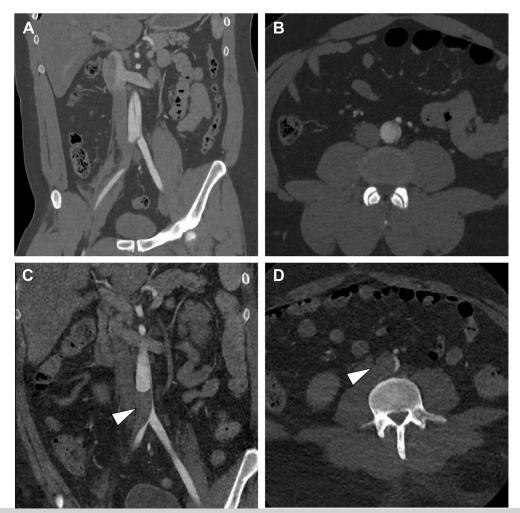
Computed tomography (CT) of abdomen and pelvis of patient 1 in coronal (A) and axial (B) planes at presentation. Similar locations on the repeat CT scan at the time of open aortic septectomy are shown in the coronal (C) and axial (D) planes. *White arrowheads* denote acute false lumen thrombosis and true lumen obstruction.
